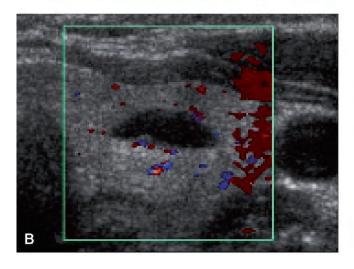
Ultrasound of a colloid nodule in the left lobe. A, Transverse. B, Color Doppler, Transverse. C, Longitudinal.
